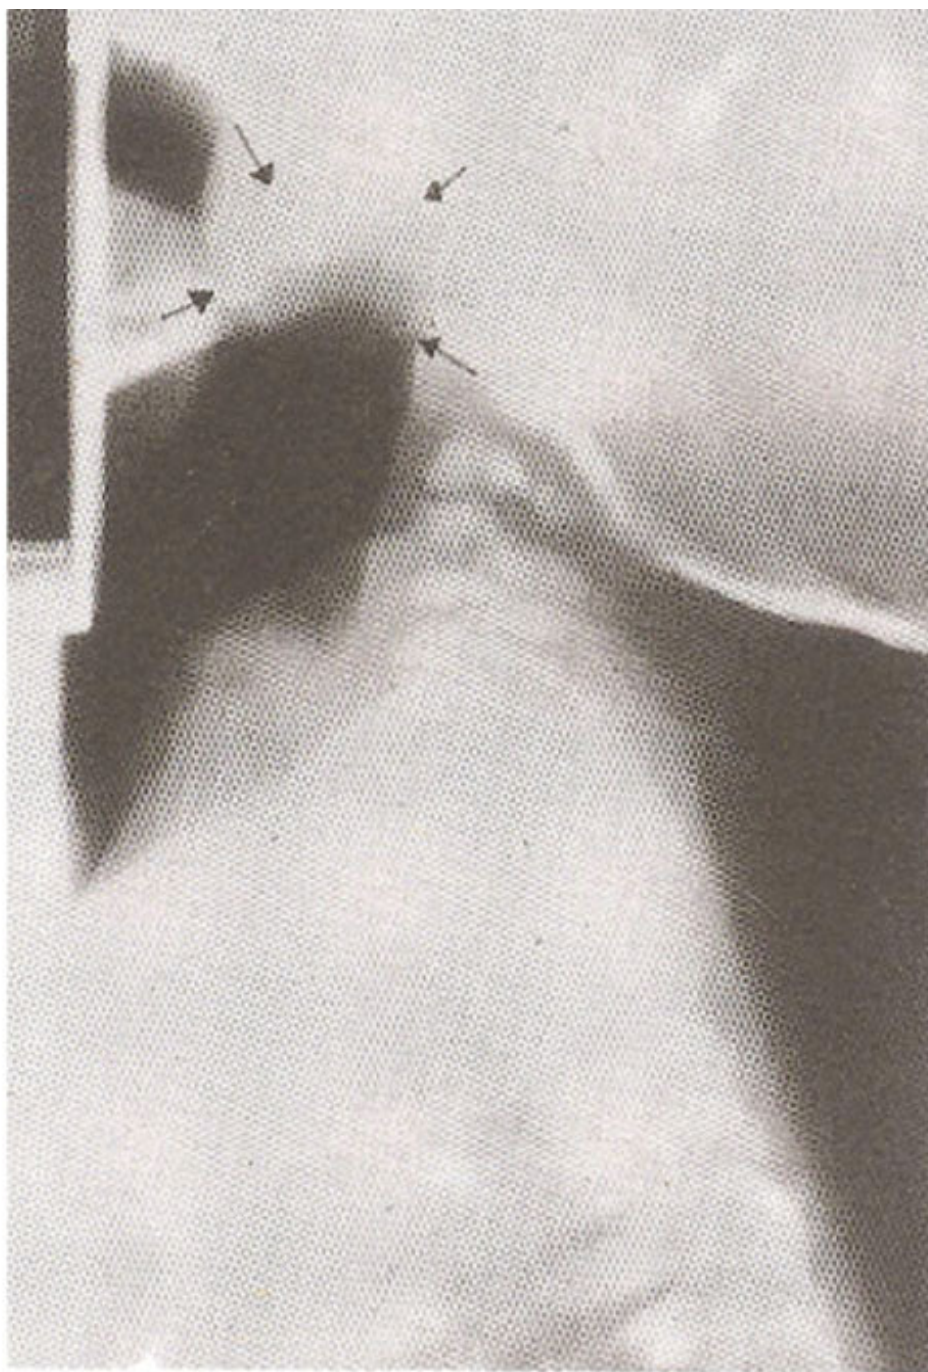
Plain X-ray neck, lateral view. Arrows marking the soft tissue shadow, which is nearly occluding the nasopharynx.
